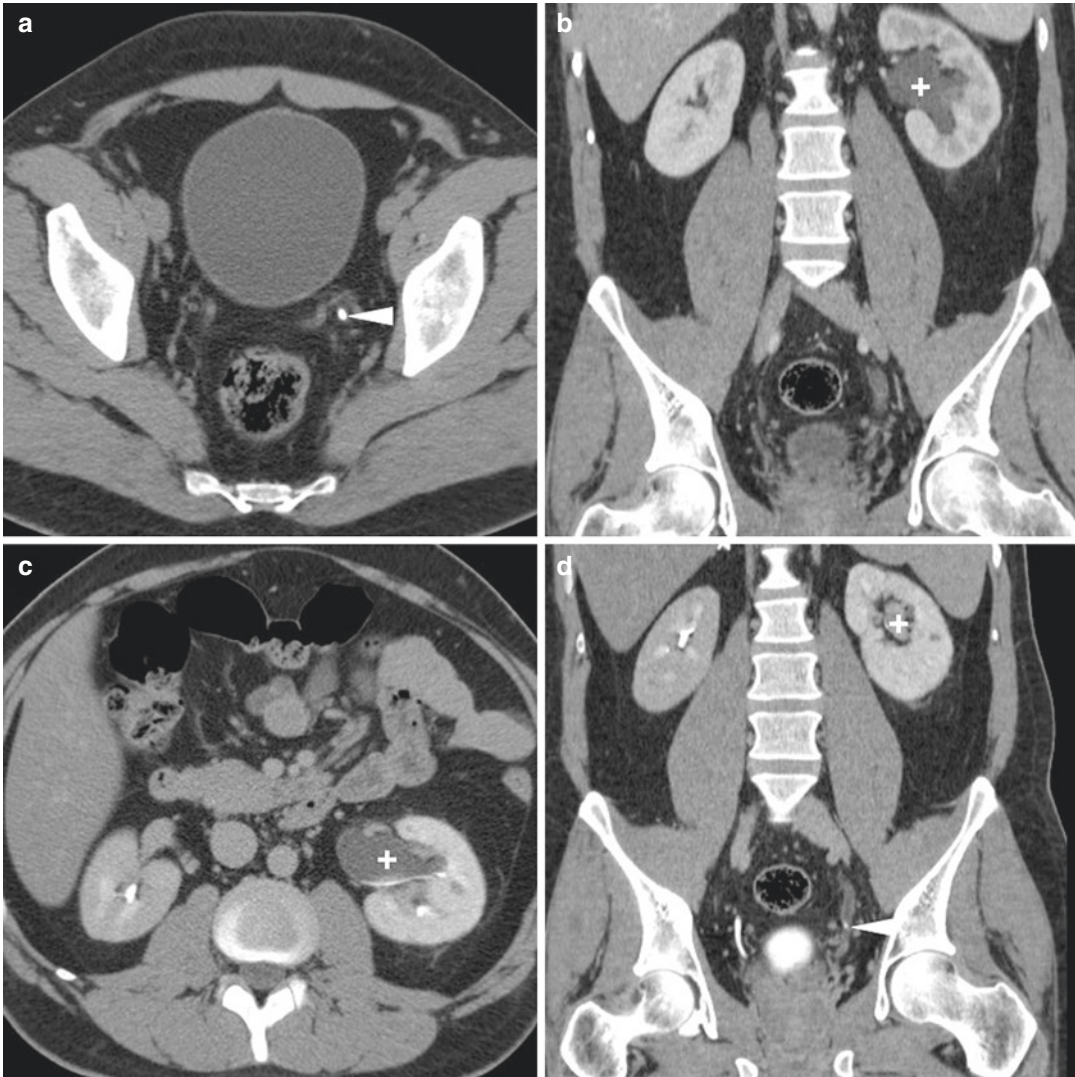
In a 49-year-old male suffering from acute left renal colic, urgent unenhanced CT (a) detected a small-sized calculus (arrowhead) of the distal ureter. The attending urologist requested study completion with intravenous contrast (b–d), which confirmed ipsilateral first-degree
